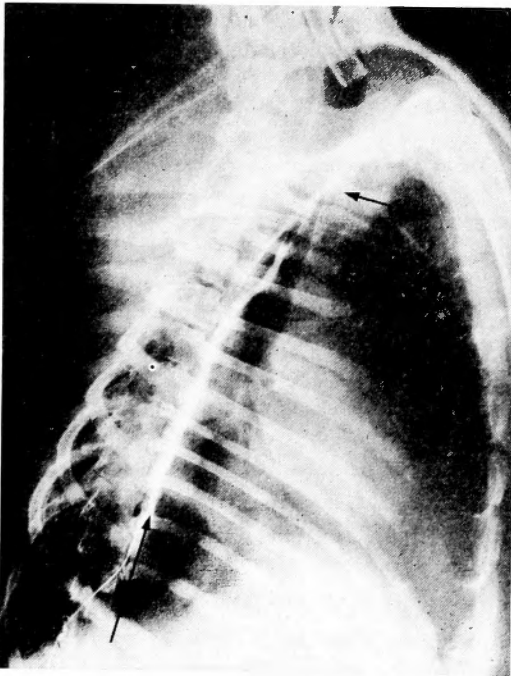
The roentgenogram of the normograde lymphangiography of the thoracic duct with the infusion of 5 ml of Lipiodol.
